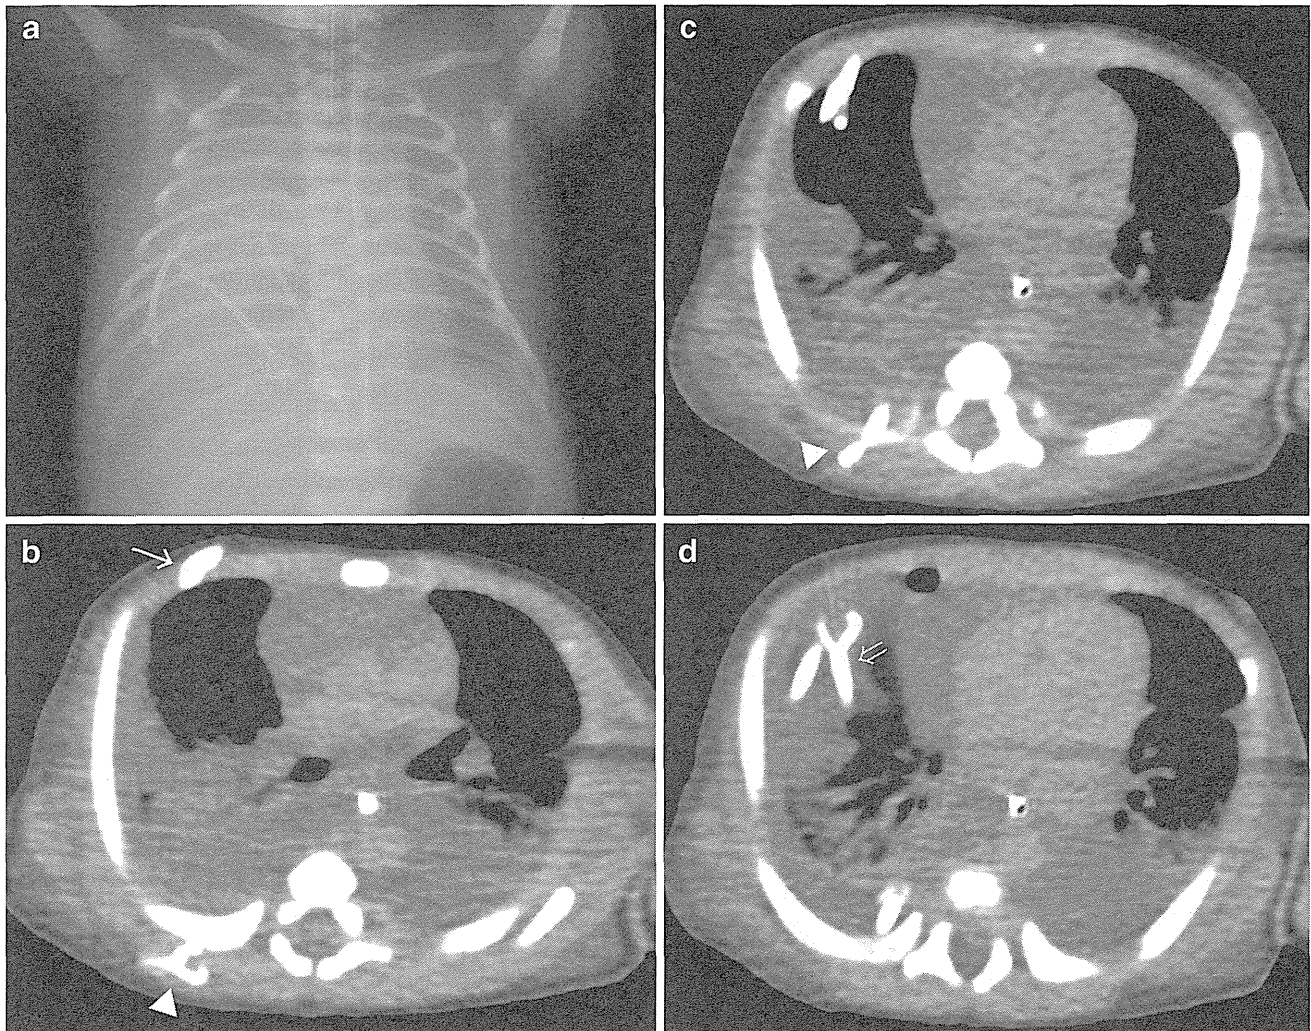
Case 3: chest X-ray at delivery (a) and chest computed tomography on day 4 postnatally (b–d). The three dislodged shunt catheters in the right thorax were detected radiographically at delivery (a). The catheter that was palpable subcutaneously (\downarrow) was removed
